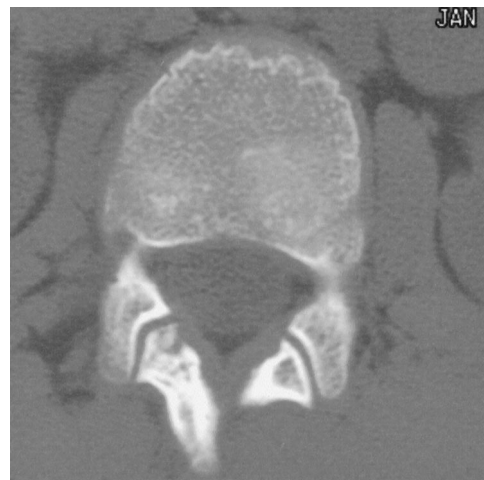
CT scan obtained in a 12-year-old boy shows an osteoid osteoma of the lamina. ILP was rejected because the nidus was too near the dura matter.
